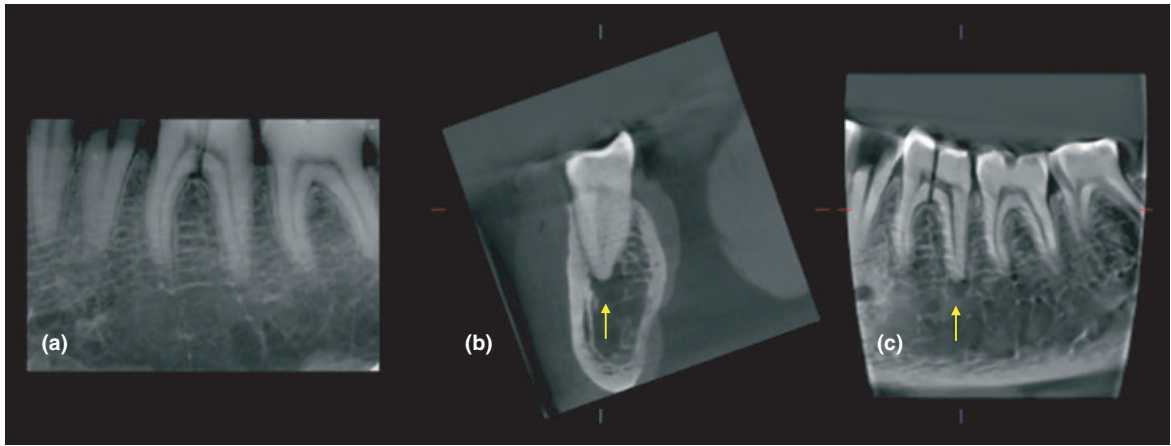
(a) Radiograph and (b) coronal and sagittal reconstructed cone beam computed tomography (CBCT) image of the same molar tooth. Note that an artificial lesion (yellow arrows) can be identified on the CBCT images but not on the periapical radiograph.
